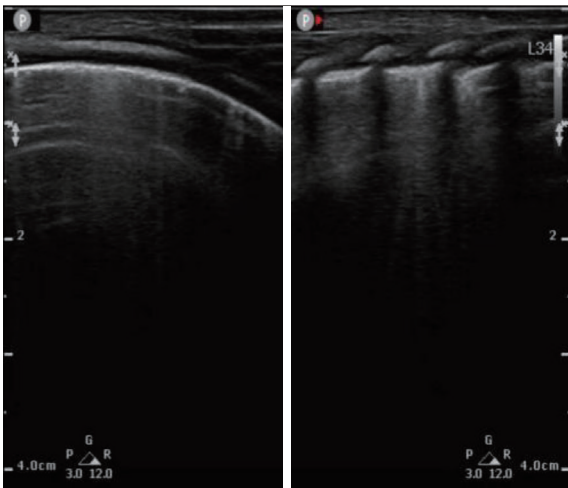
Lung ultrasound showed “alveolar interstitial syndrome” in BPD patients. BPD, bronchopulmonary dysplasia.
